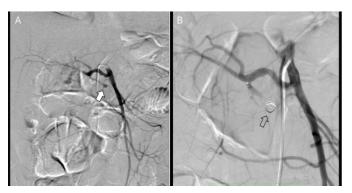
CTA of a 47-year-old man who presented with massive hematochezia due to duodenal ulcer. Selective hepatic artery angiography showed a PA arising from the gastroduodenal artery (A). After the lesion was super selectively catheterized, the PA embolized with coil (B)
